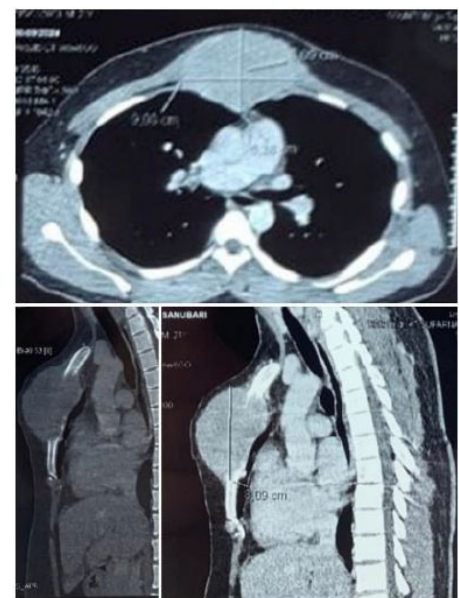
CT-Scan Images of the Chest Wall Tumour.
